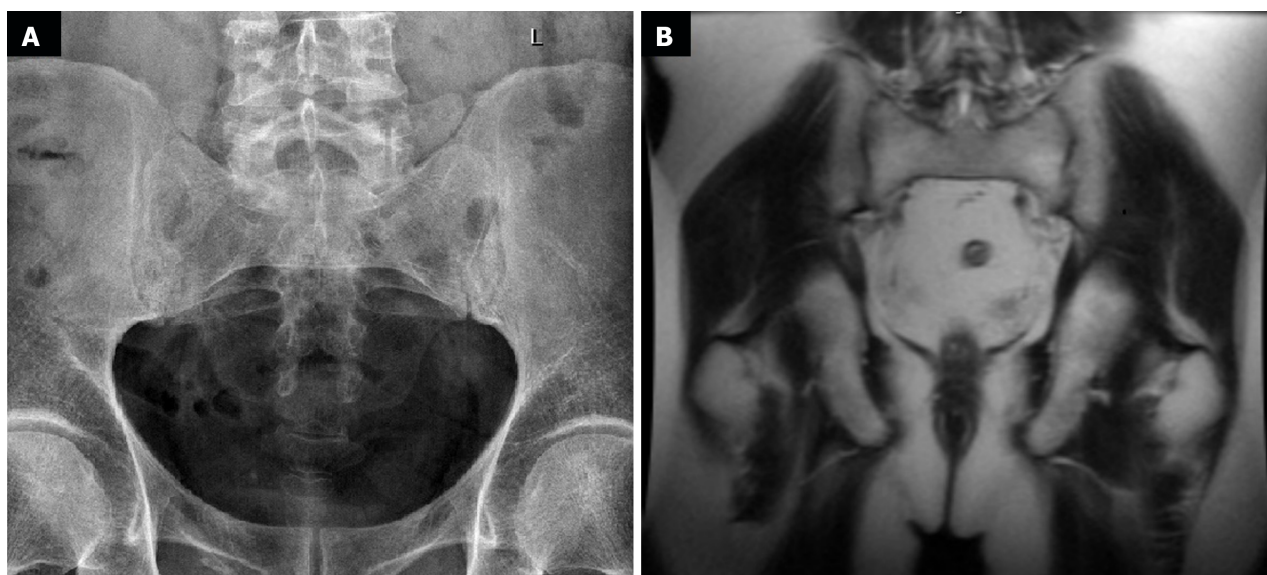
Images revealing bilateral sacrolitis. A: On the X-ray; B: In magnetic resonance imaging.
